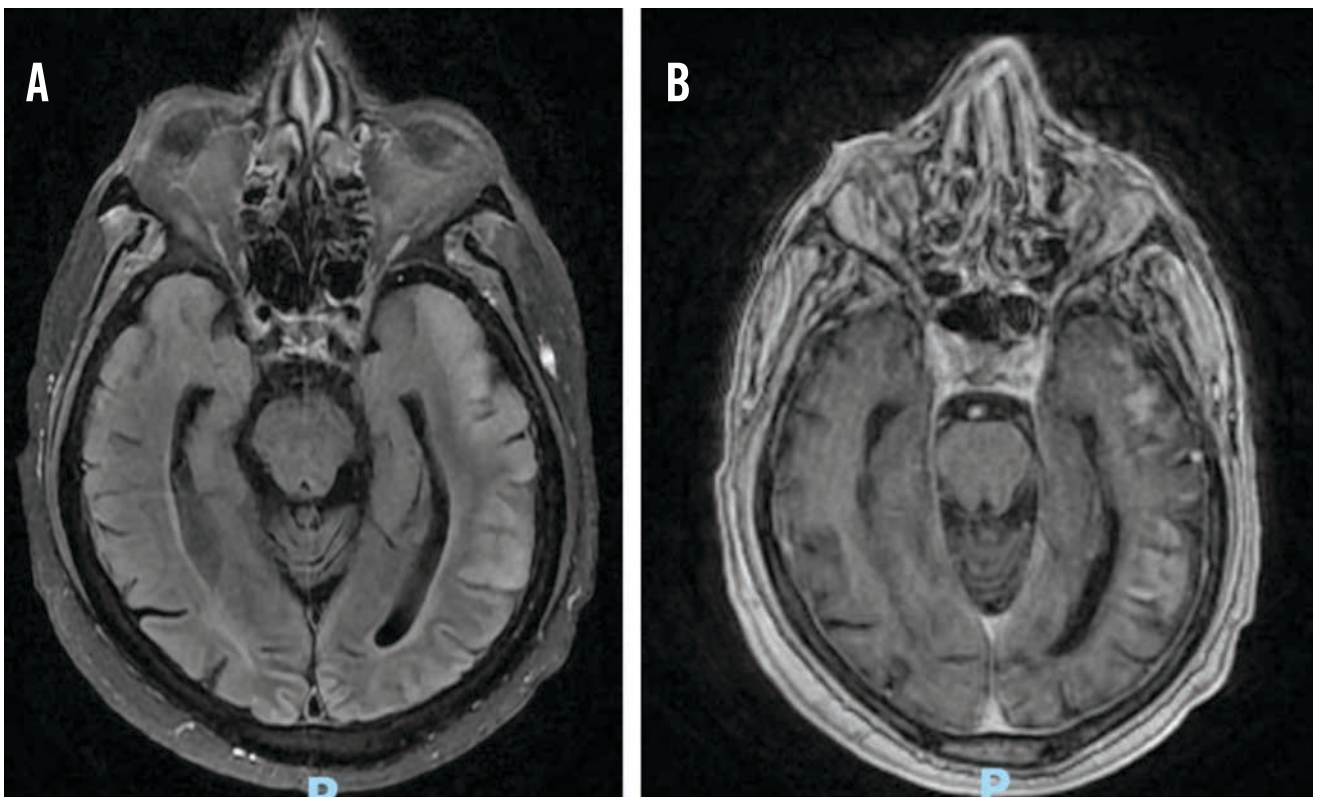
A - Cortical T2/FLAIR hyperintense signal in the left temporal, parietal, and occipital lobes; B - associated cortical enhancement in these regions
